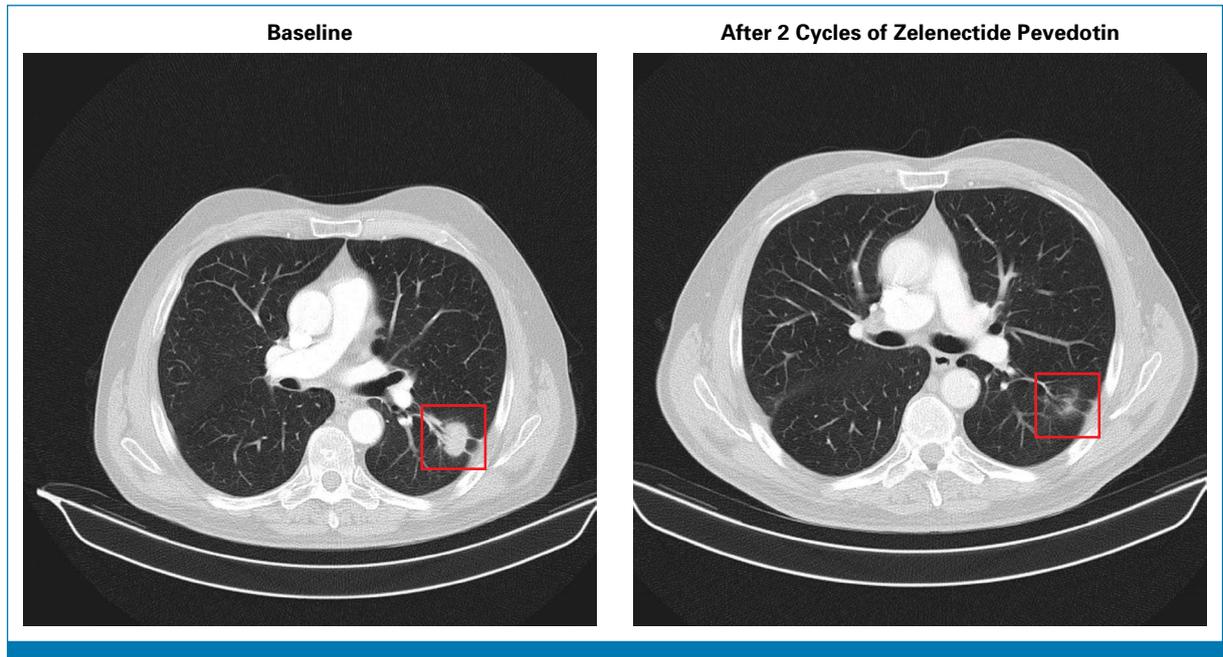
Representative computed tomography scans show a near CR in a patient with metastatic urothelial carcinoma. Metastatic target lesions in the left lung were reduced by 90% after two cycles of zelenectide pevedotin monotherapy. The patient went on to achieve a CR after four cycles. The CR was maintained for over 18 months as of the data cutoff date of March 4, 2024. CR, complete response.
